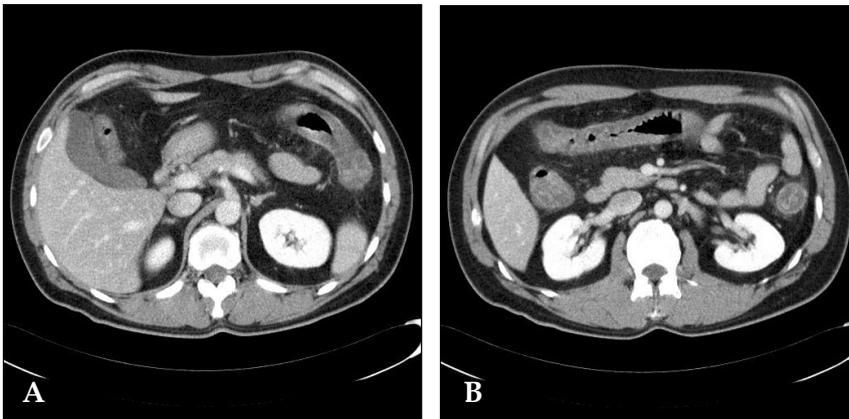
Abdominal and pelvic CT scans show a patent superior mesenteric artery (A) and edematous circumferential wall thickening of the ascending, transverse, and descending colon (B).
